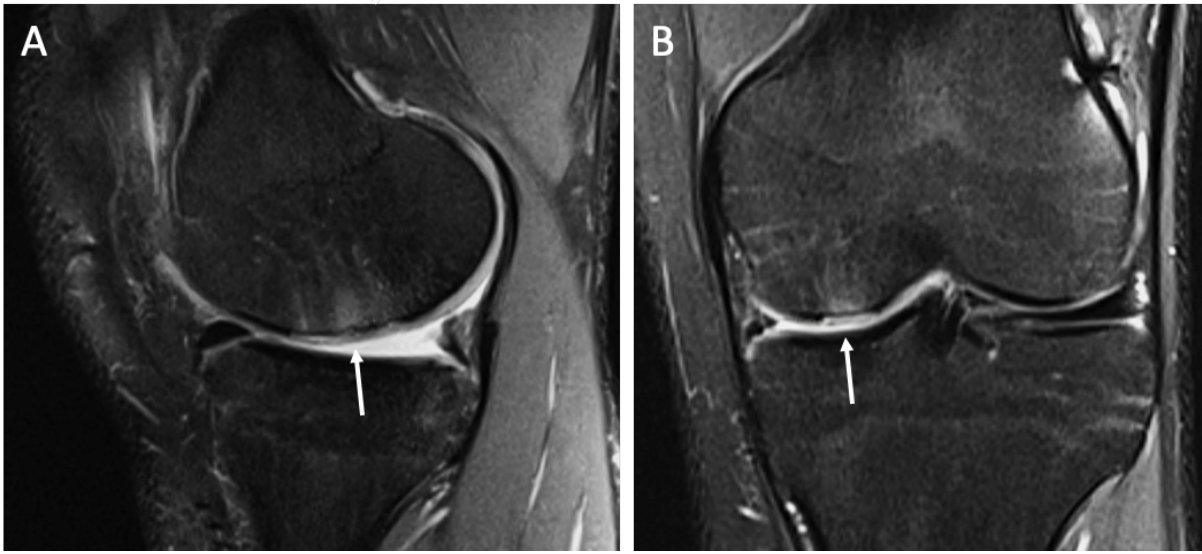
Magnetic resonance imaging (3 Tesla) of a subchondral bone edema and delaminated fibrocartilage following microfracture. MRI also indicates a posterior meniscus root tear. Sagittal (A) and coronal (B) fat-suppressed intermediate-weighted images demonstrating a subchondral bone edema and delaminated fibrocartilage following failed microfracture.⁵³
